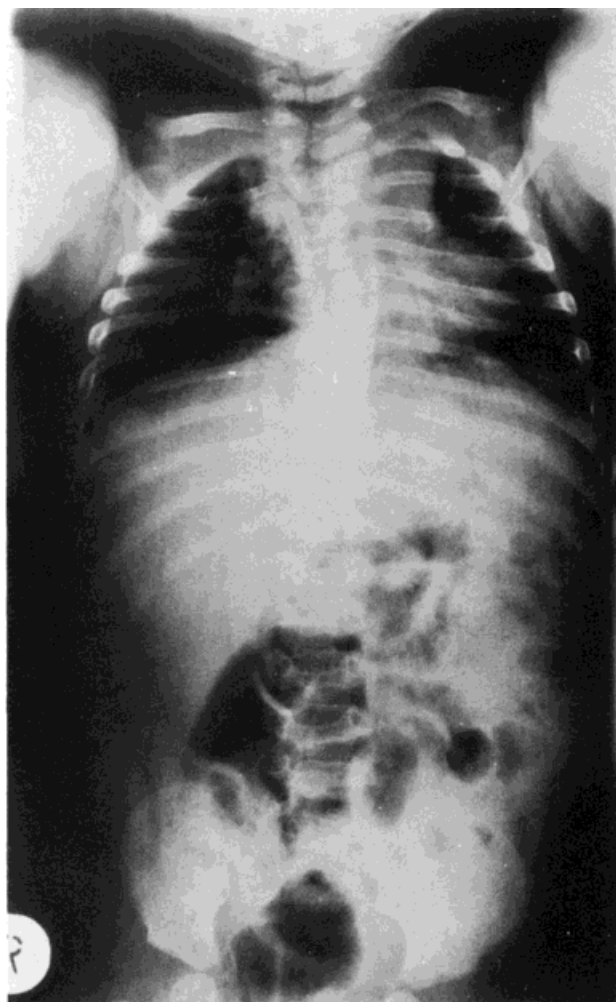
Roentgenogram of patient II-2 of family 1 at the age of 5 months old. She has severe spinal dysplasia with sagittal cleft vertebrae, a vertebral bar on the right side and a first right rib hypoplastic or absent.
